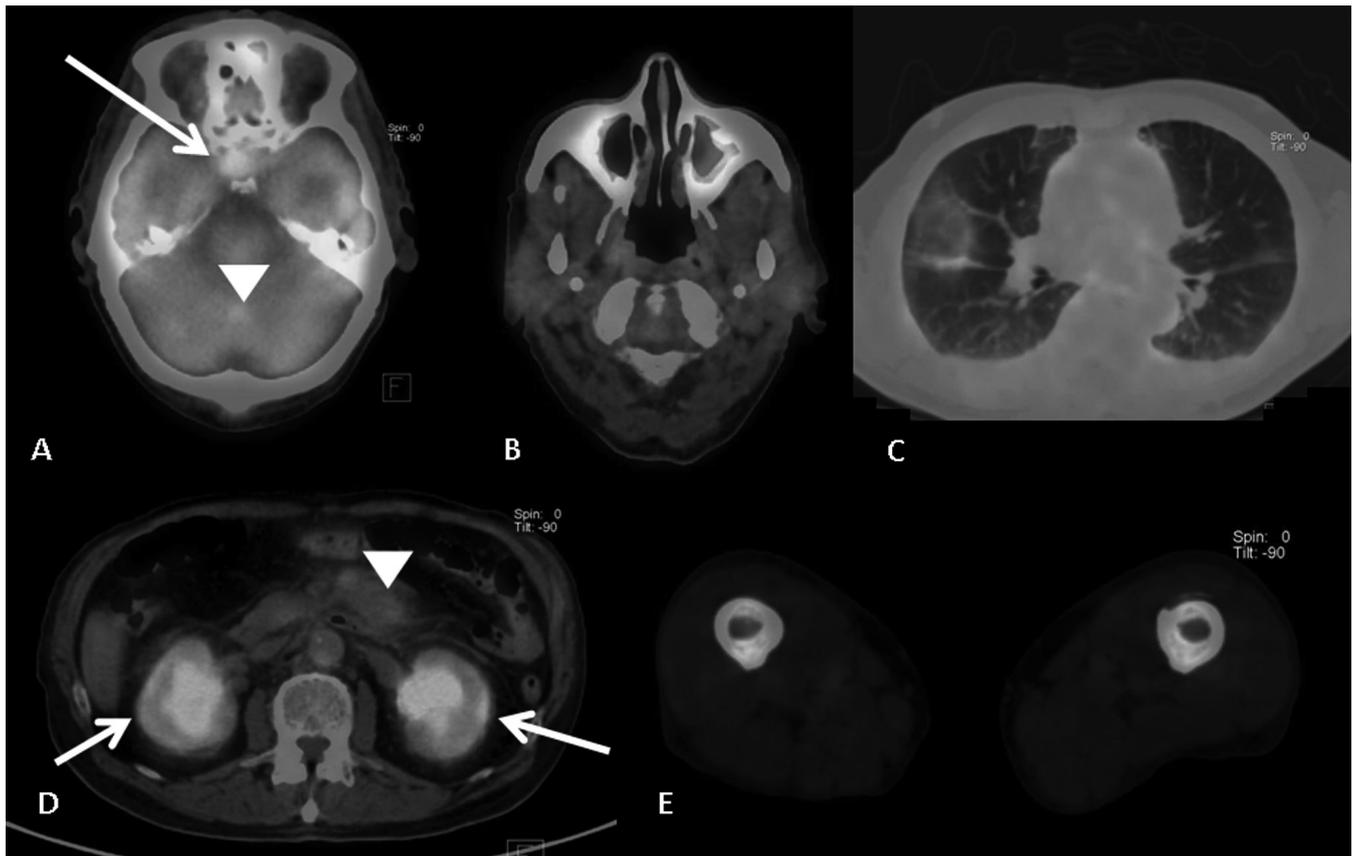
FDG PET images superimposed on CT slices. A. Pituitary stalk (white arrow) and cerebellar (white arrowhead) involvement. B. Maxillary sinuses involvement. C. Moderate pulmonary involvement. Of note, there is no FDG intake of the aorta wall, in contrast with the CT pattern (*cf.* Fig. 2B). D. Bilateral perirenal involvement (white arrows) and mesenteric panniculitis (white arrowhead). E. Bilateral femoral inflammatory osteosclerosis of the diaphyses.
